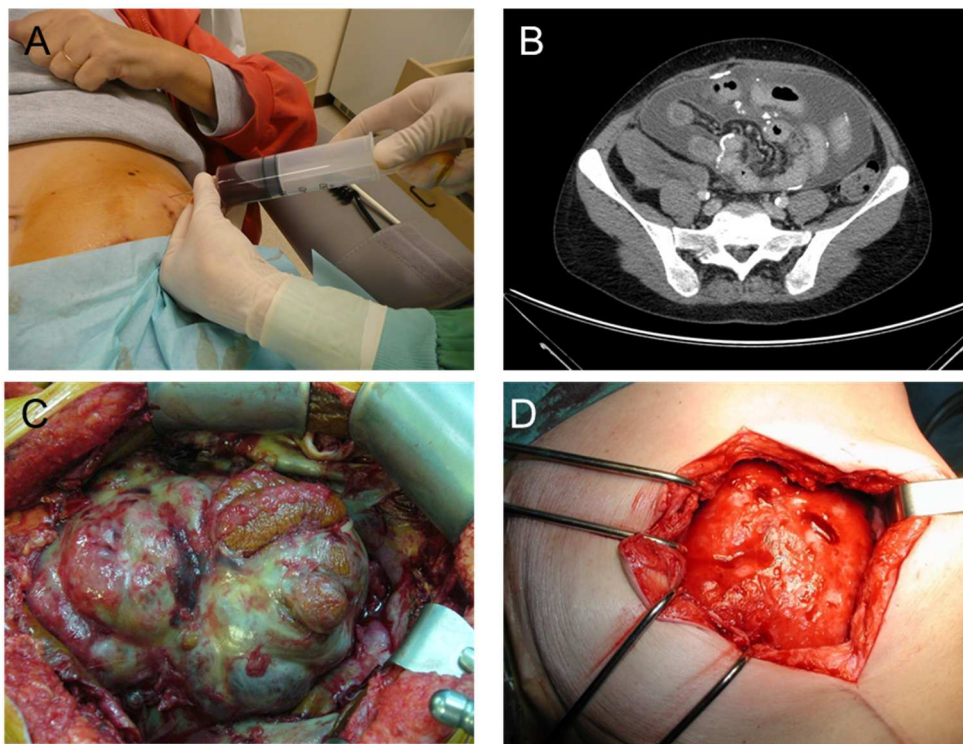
Encapsulating peritoneal sclerosis. (A) Bloody dialysate at early stages of the disease. (B) Typical features of EPS on computed tomography, with thickening and calcifications of the peritoneal layers. (C-D) Macroscopic appearance of EPS, with a fibrotic cocoon that encapsulates the bowel and contributes to intestinal obstruction. Courtesy of Prof. Eric Goffin, Christian Verger, and Titus Augustine.
